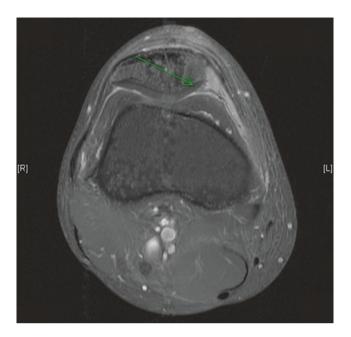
Contrast-enhanced T2-weighted fat-saturated MRI image of a clear cell sarcoma of the knee with patellar invasion. The tumor was confirmed to have an *EWSR1* rearrangement
